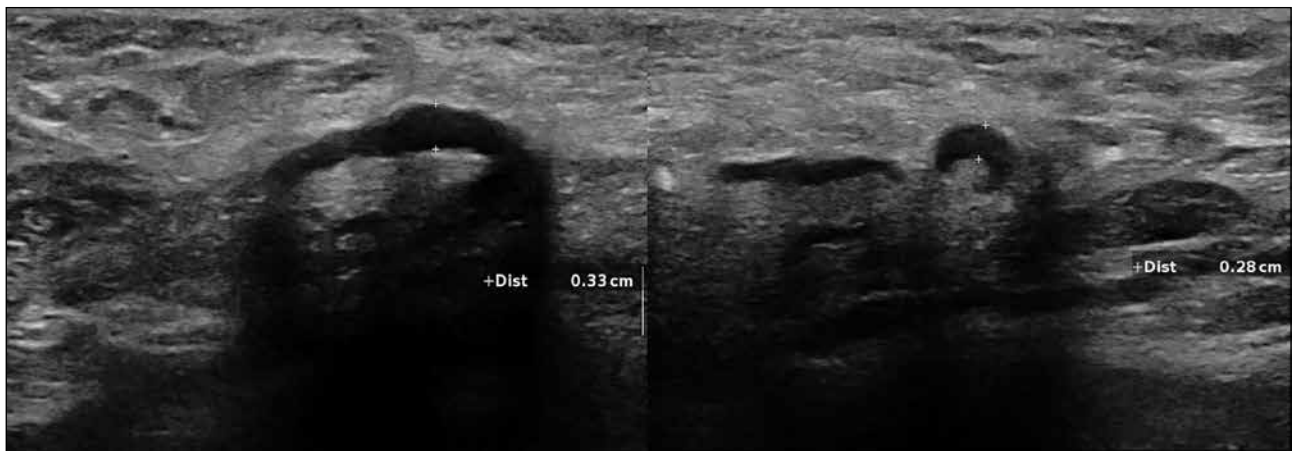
Ultrasound of the left axilla showed enlarged lymph nodes with cortical thickening.
